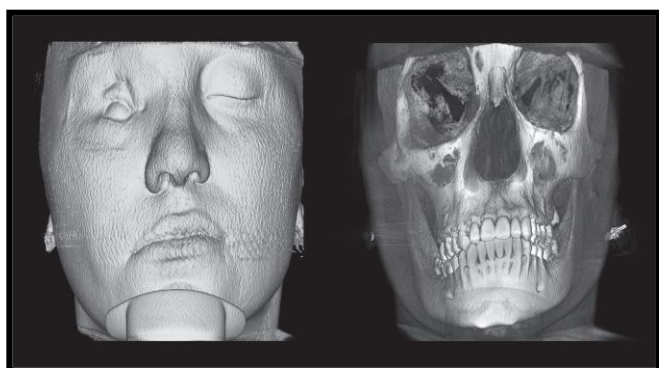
Three-dimensional reconstruction of craniofacial hard and soft tissues in a 24 years old woman. The images were obtained with cone beam computerized tomography (White Fox, De Goetzen, Olgiate Olona, Varese, Italy; X-ray tube voltage 105 KV, X-ray tube current 8 mA). A cephalometric, expanded field of view was used (diameter 200 mm, height 170 mm). A: soft tissue reconstruction. A notable facial asymmetry can be observed (the left labial commissure is more cranial than the right one, the right nasal ala is bigger than the left one), together with alterations in the right orbital area. B: hard tissue reconstruction. The occlusal plane is asymmetric, and the right orbital cavity altered
